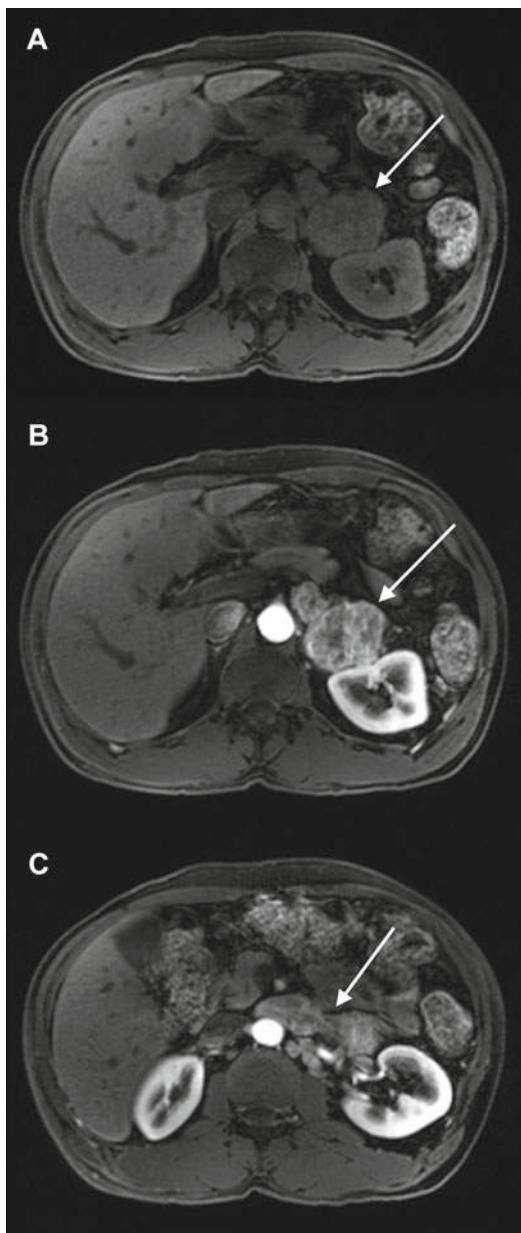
Fifty-two-year-old man with hypertension. Precontrast, axial T1-weighted image with fat saturation (a), demonstrates a large left adrenal mass (arrow). On the postcontrast axial T1-weighted image with fat saturation (b), there is heterogeneous enhancement (arrow). (c) (postcontrast axial T1 weighted image with fat saturation) demonstrates invasion of the left renal vein (arrow). This was a pathologically confirmed pheochromocytoma
